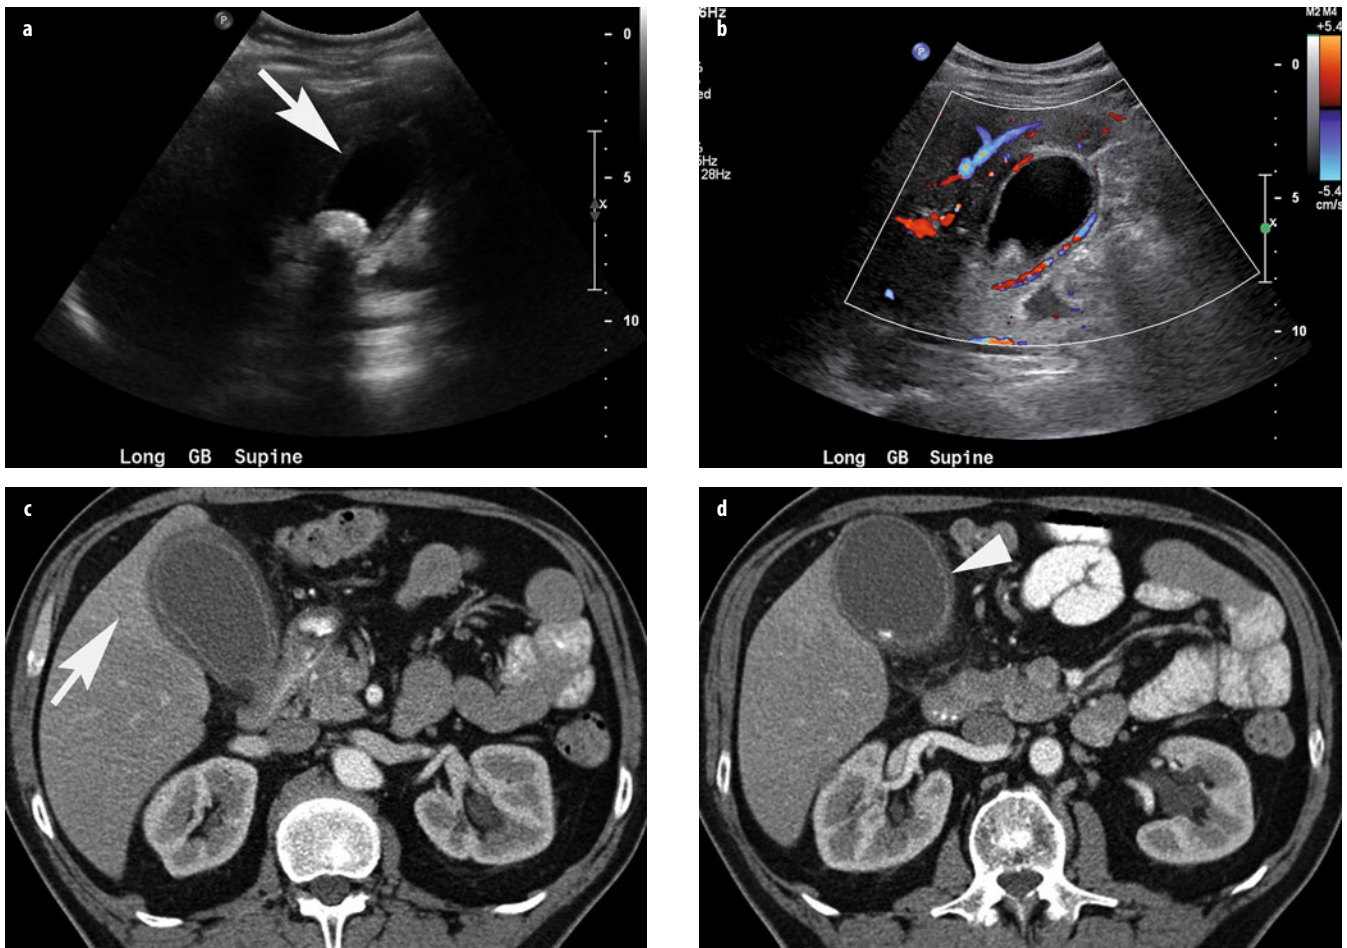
a-d. Acute cholecystitis. a, b Longitudinal ultrasound (US) shows a large stone impacted in the gallbladder neck, gallbladder wall thickening (*arrow*), and gallbladder wall hyperemia on color Doppler. c, d Contrast-enhanced computed tomography (CT) with intravenously and orally administered contrast media shows a distended gallbladder containing a stone, gallbladder wall thickening (*arrowhead*), pericholecystic inflammation, and hyperenhancement of the adjacent liver (*arrow*)
